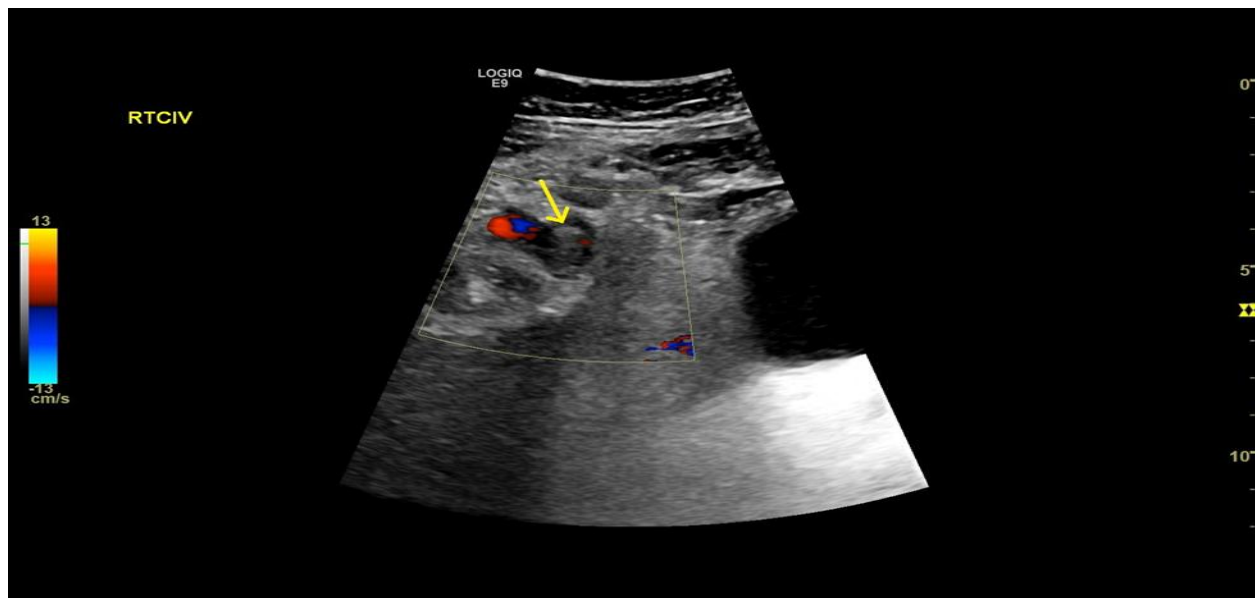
Ultrasound Doppler study revealed right non-compressible CIV showing echogenic lumen however with areas of minimal peripheral flow (yellow arrow? early thrombus recanalization)
